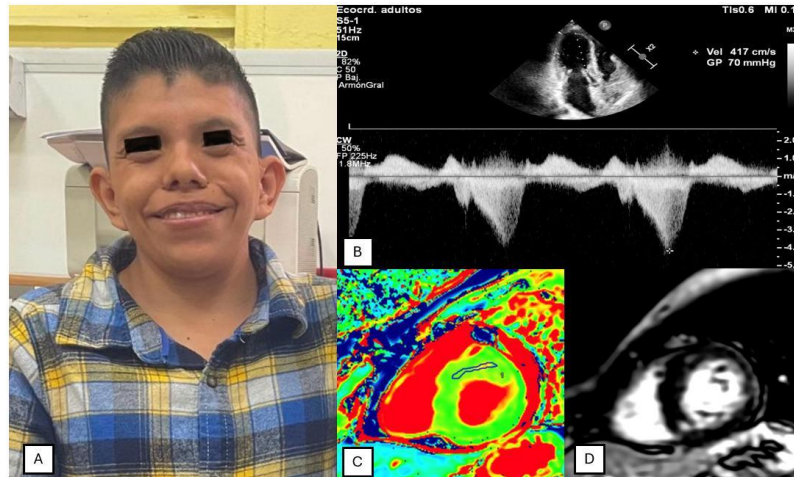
A. Clinical view of the patient. B. Transthoracic echocardiogram, apical 3-chamber view: elevated gradient in the left ventricular outflow tract (LVOT). C. Cardiac MRI, short-axis view: hypertrophic obstructive cardiomyopathy (HOCM) with septal predominance and elevated native T1 mapping (1108 ms). D. Late gadolinium enhancement (LGE) at the right ventricular insertion points within the hypertrophied myocardium.
